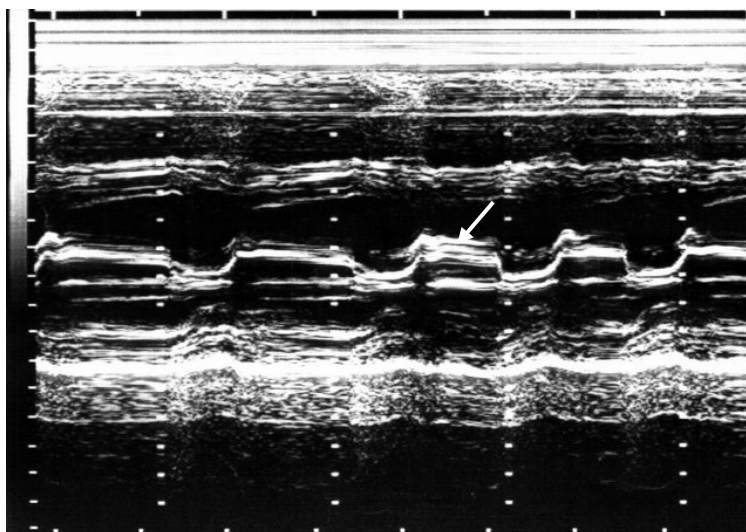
M-mode echocardiogram (parasternal a position). Mitral stenosis: fibrosis of leaflets of mitral valve and restriction of mobility of a back leaflet of mitral valve (arrow)
